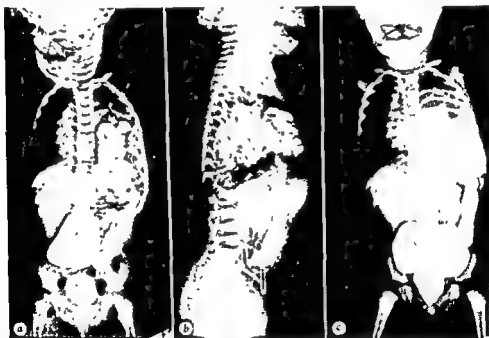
Congenital pleuropertoneal hiatus diaphragmatic hernia in a baby girl 13 months of age. Herniation of the entire right portion of the colon, the transverse colon, and the small intestine into the left portion of the thoracic cavity. Roentgenograms were taken on admission of the patient (a) and (b). The small intestine herniated into the left portion of the thoracic cavity, the stomach is below the diaphragm (c). Herniation of the entire ascending and transverse colon into the left portion of the thoracic cavity.
